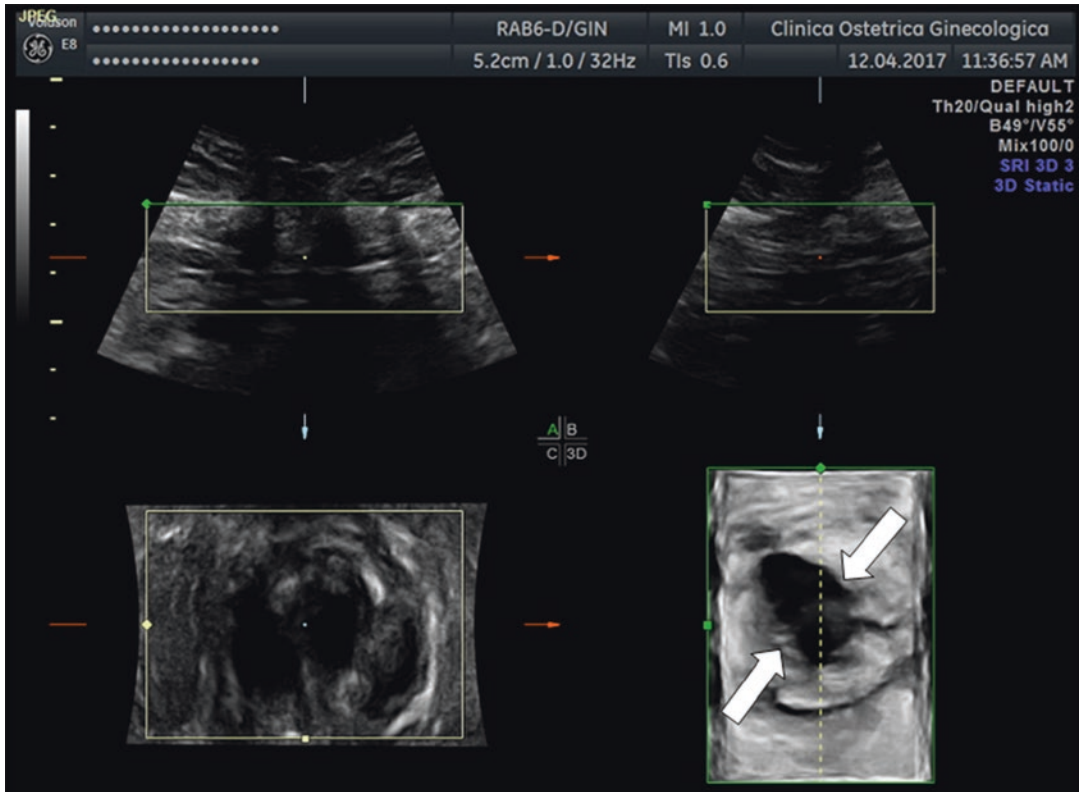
Three-dimensional ultrasonographic appearance of a scar endometriosis (straight arrows) in a 32-year-old woman with a cesarean section 6 years before
